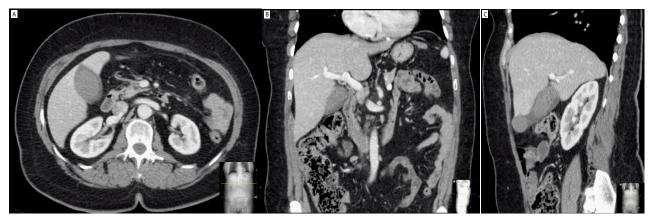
(A) Axial, (B) Coronal and (C) Sagittal sections of an abdominal CT scan. A dense content fills the lumen of the gallbladder, which is slightly distended (38 mm in transverse diameter). A probable large calculus can be seen at the fundus of the gallbladder in image C. Note the close relationship between the right colon, duodenum and distal portion of the stomach, in image B.
